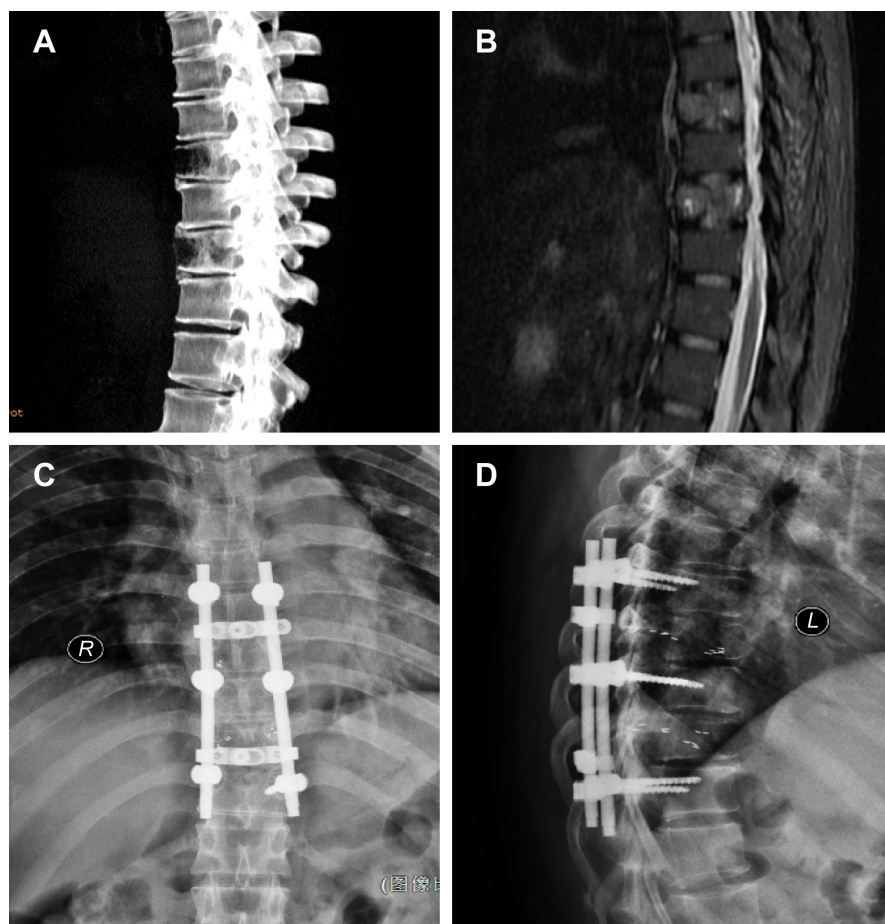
Computed tomography (CT) and magnetic resonance imaging scan of spine.
